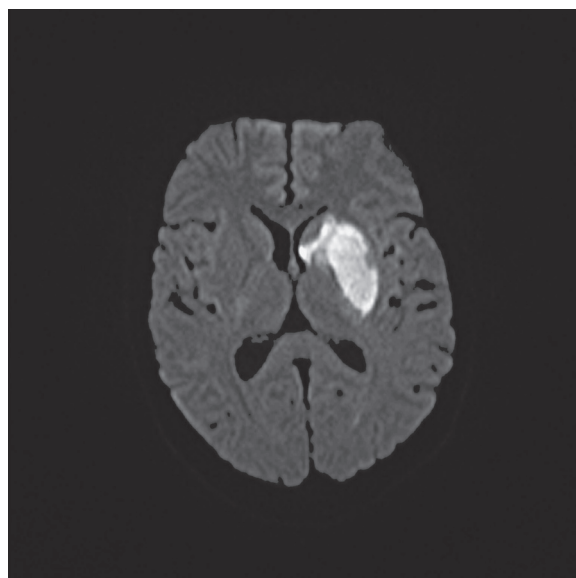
In the control MRI 24 hours after the procedure a diffusion positive infarct of the basal ganglia is visible, mRS 1, NIHSS 1.
